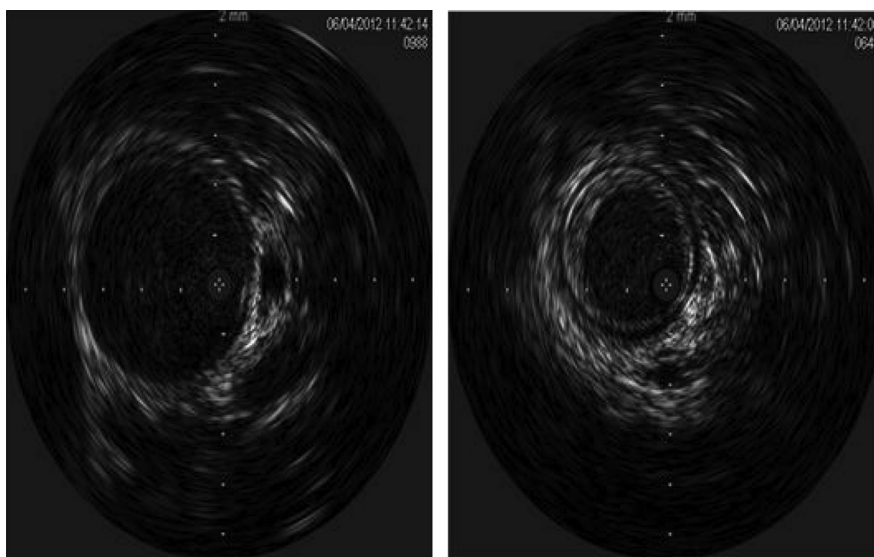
Intravascular ultrasound (IVUS) imaging differentiated (*left*) a normal segment of proximal iliac artery from (*right*) a section of proximal iliac artery that demonstrated intimal hypertrophy.
